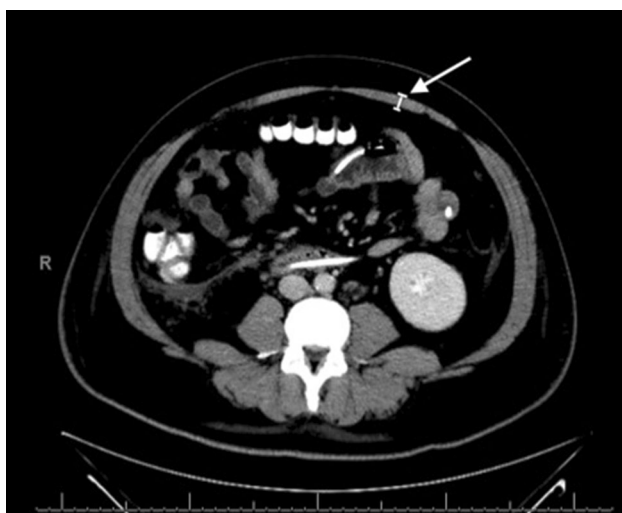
Example CT with sample rectus abdominis width measurement denoted by the *arrow*
